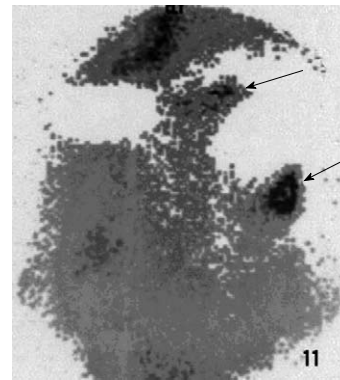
Immunoscintigraphy, planar, posterior view. Accumulation of radiopharmaceutical (INDIMACIS 19-9) in liver metastases (arrows).
